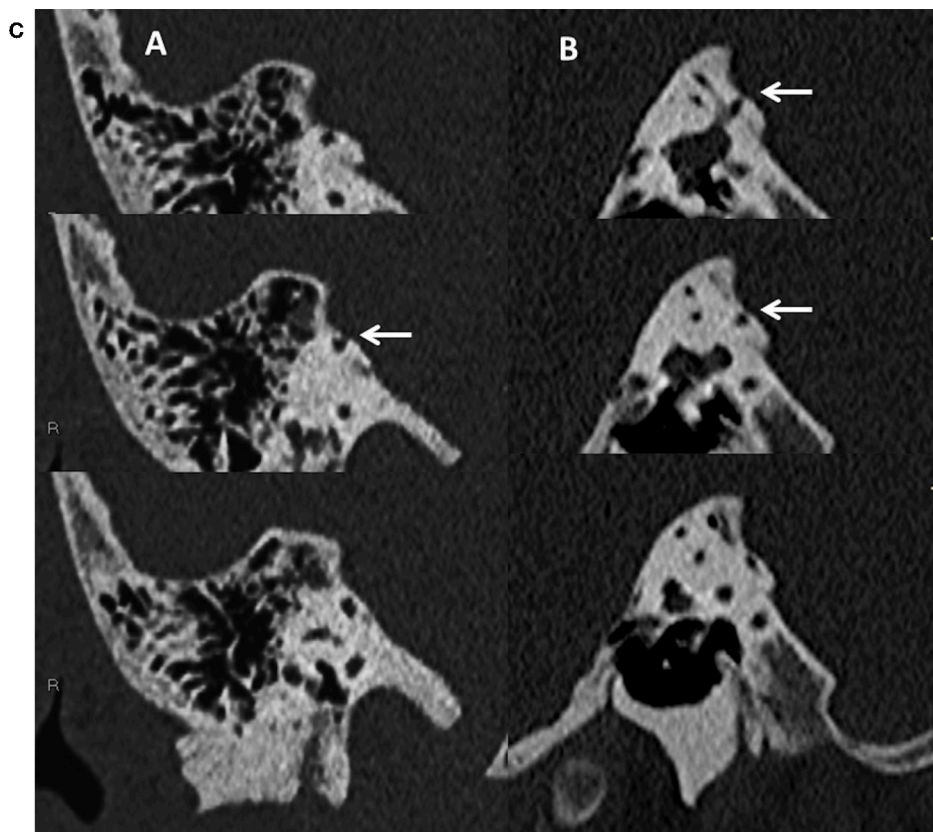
(A) PTA in a child presenting with mixed hearing loss (child 1). (B) Video head impulse test in same child with at least 2 covert replicable saccades in the right posterior semicircular canal (arrow). (C) Coronal (A) and sagittal (B) reconstructions of a high resolution CT scan with consecutive slices demonstrating dehiscence of the right posterior semicircular canal (arrows).
